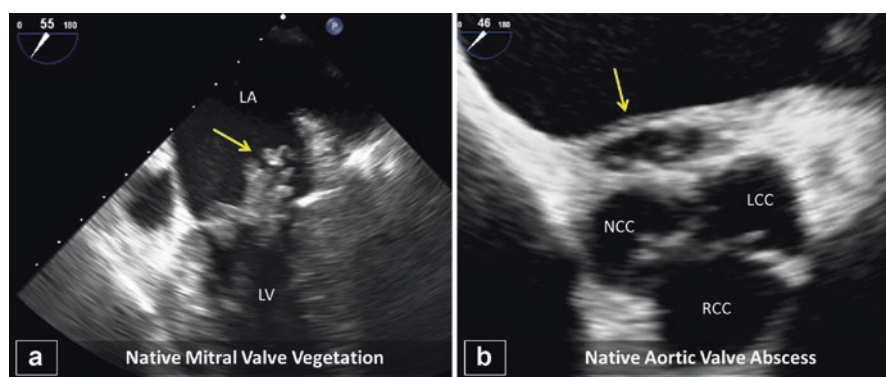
Endocarditis. (a) Vegetation visualized on atrial side of the mitral valve on TEE. (b) Abscess formation adjacent to the aortic valve. *TEE* Transesophageal echocardiogram, *LA* Left atrium, *LV* Left ventricle, *NCC* Noncoronary cusp, *RCC* Right coronary cusp, *LCC* Left coronary cusp
